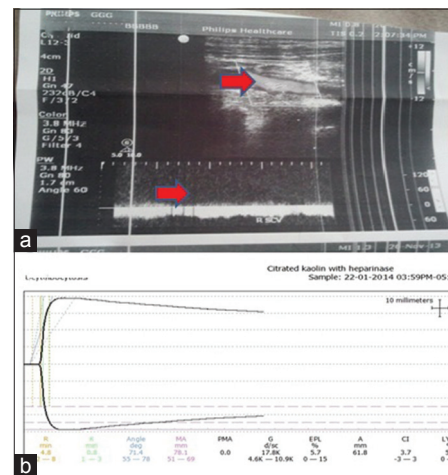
(a) Doppler ultrasonography showing thrombus in right internal jugular vein with no flow. (b) Thromboelastogram showing hypercoagulability
